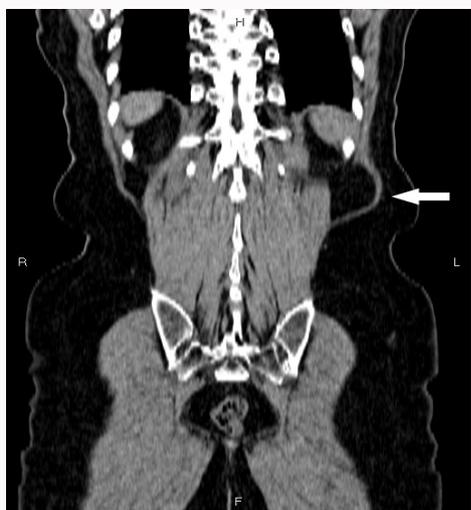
Coronal CT image shows adipose tissue herniation below 12th rib.
